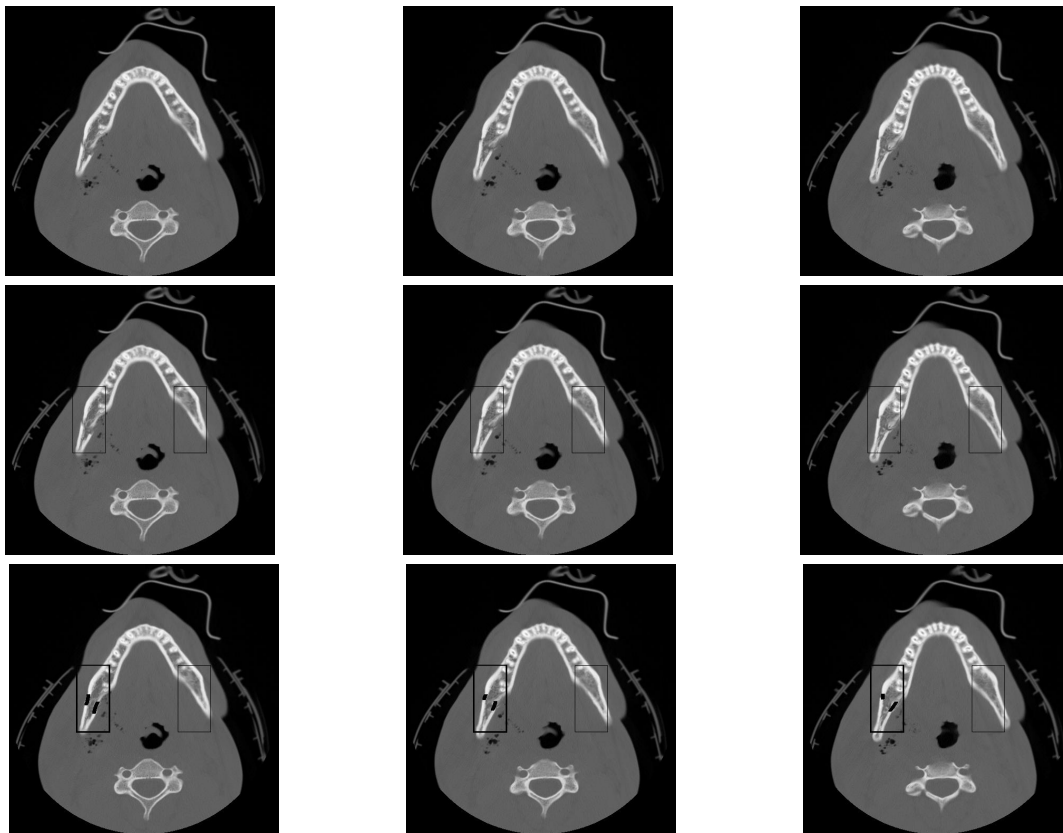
Two-phase fracture hairline detection scheme on a real patient CT image sequence
